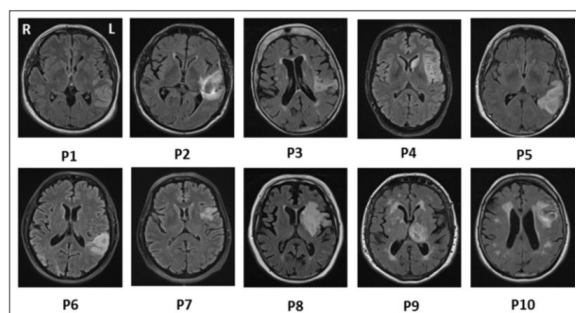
Individual lesion locations as represented on MRI-images (T2-weighted, flair axial). MRI scans were taken within two weeks after stroke. Left and right are inverted. P = patient; L = left; R = right.
